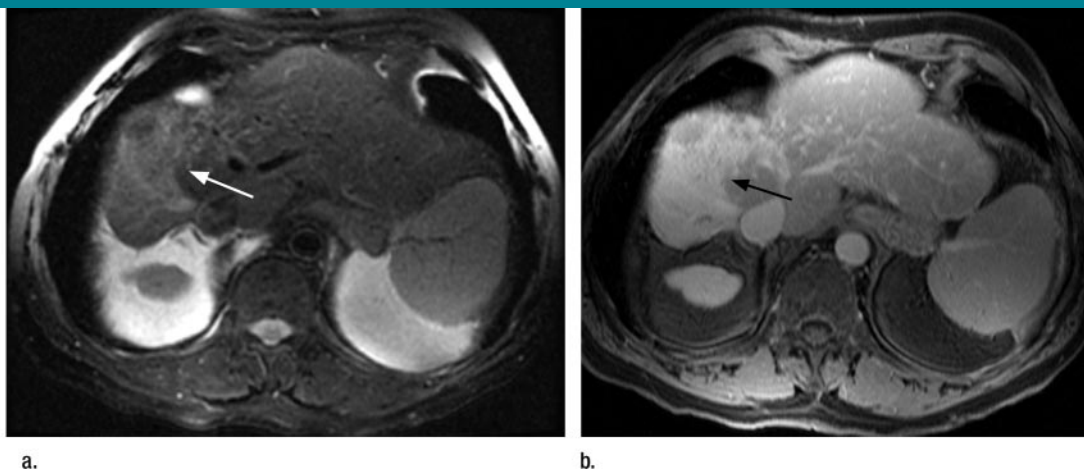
Transverse MR images in 72-year-old man with alcohol-related cirrhosis. There is confluent hepatic fibrosis (arrow), which is seen as a wedge-shaped area of increased signal intensity on (a) T2-weighted fast-recovery FSE (3200/92) image, associated with capsular retraction. The area of fibrosis shows intense delayed enhancement relative to adjacent parenchyma on (b) T1-weighted SPGR image (155/1.3, 70° flip angle) acquired in the venous phase. This morphology and pattern of enhancement is atypical for HCC.
